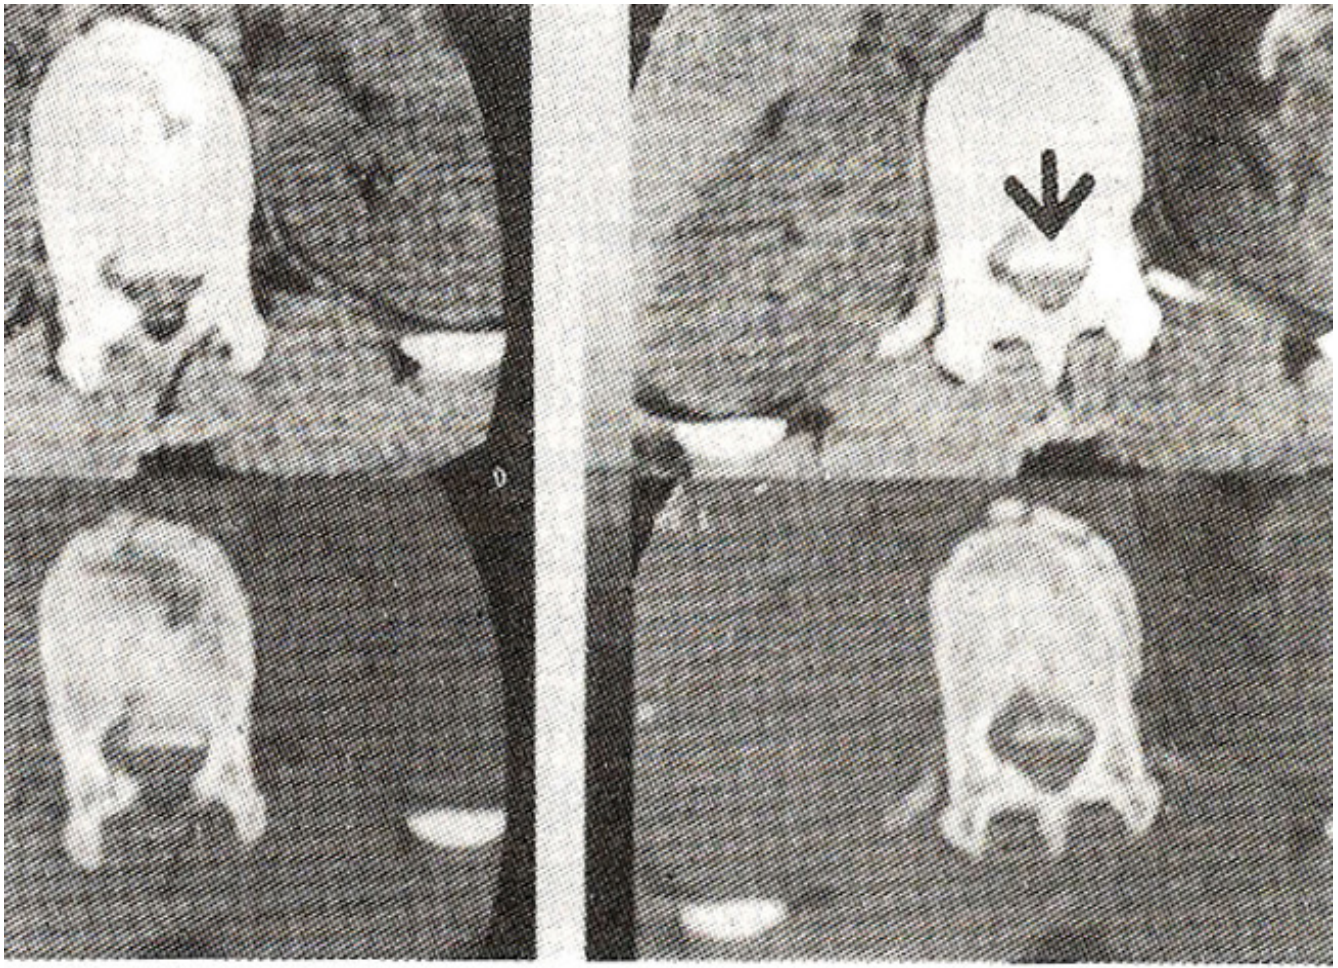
Axial CT showing retropulsed fragment within the spinal canal.
